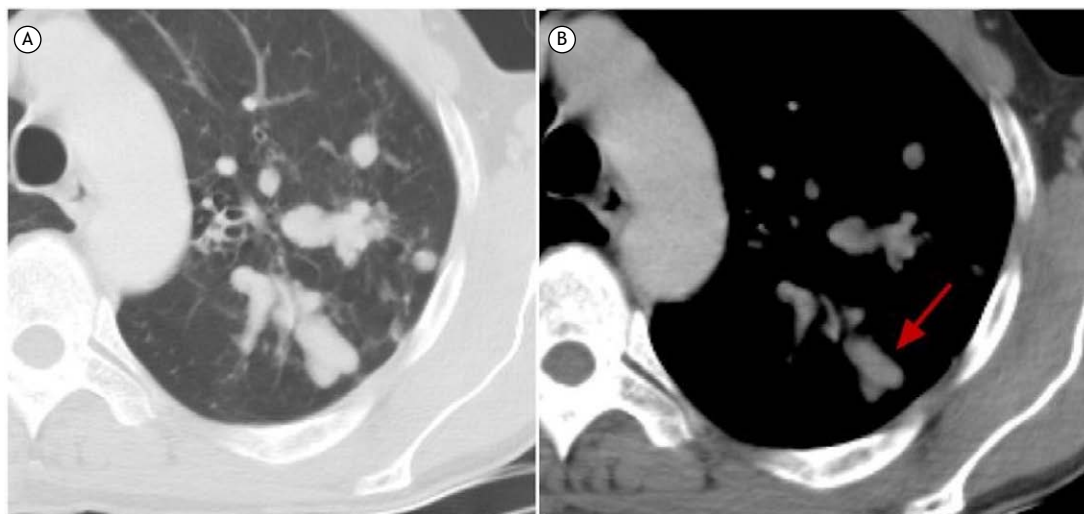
Axial CT scans of a patient with allergic bronchopulmonary aspergillosis (ABPA). In A, a CT scan with lung window settings showing bronchoceles. In B, a CT scan with mediastinal window settings showing increased attenuation (red arrow) within a bronchocele, suggesting the diagnosis of ABPA.
